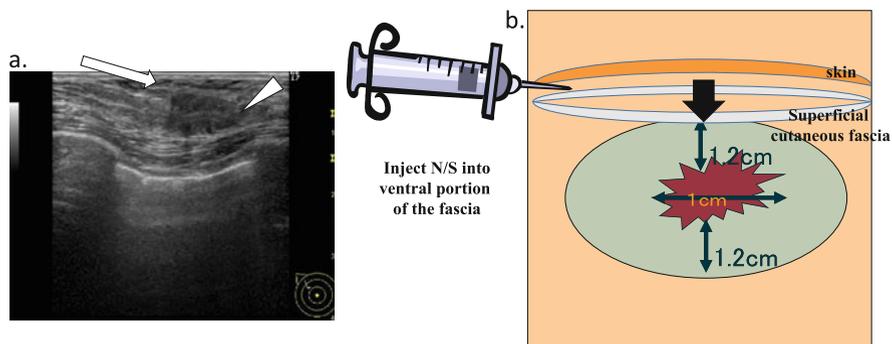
Protecting the skin is achieved by injecting saline in the space between the skin and the superficial cutaneous fascia. (a) Image with ultrasonography. Although the lesion is closed, the injection made the gap between the skin and the superficial subcutaneous fascia. This lesion is a candidate because the gap could be expanded with injecting saline. (b) The space between the skin and the subcutaneous fascia can be expanded by injecting saline. The ice ball engulfs the fascia
